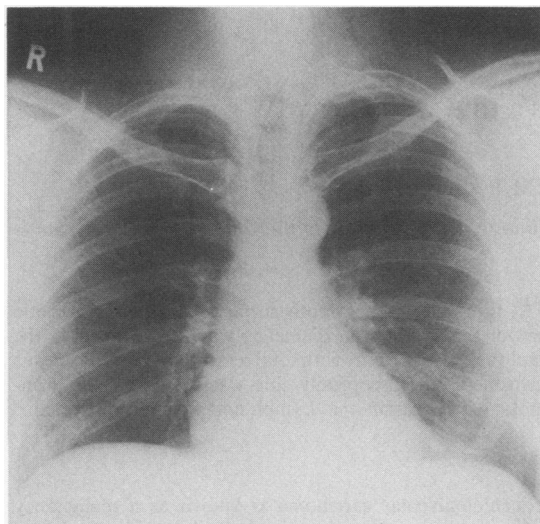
Chest radiograph three months later, showing resolution of the pleural effusion.
